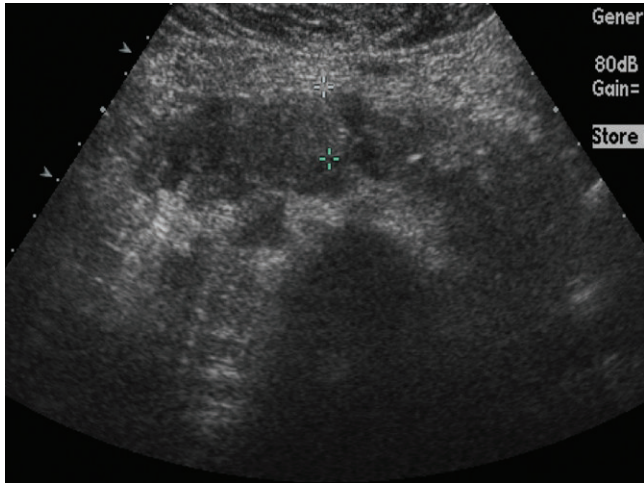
Ultrasound image at mid abdomen demonstrates a lobulated, rather homogeneous mass anterior to the aorta (calipers).
